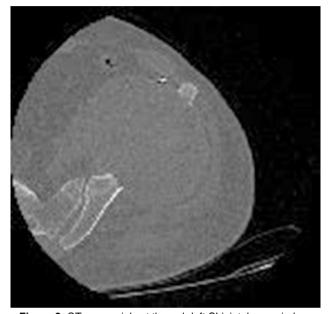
CT scan axial cut through left SI joint, bone window, reveals a large soft tissue mass causing destruction of iliac blade. Note a metallic density focus anterolateral to mass representing fixation wire.
